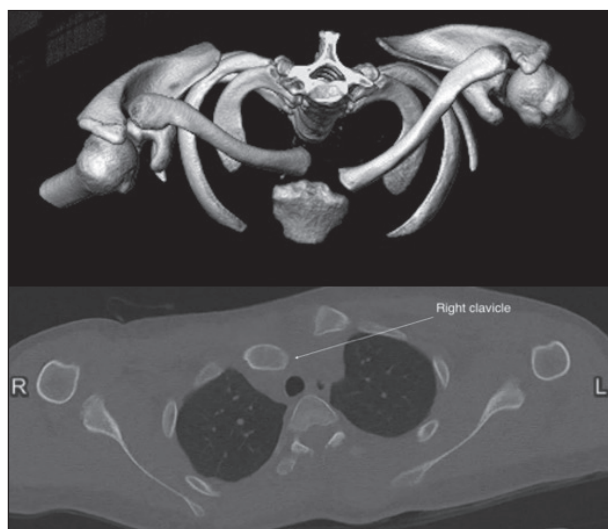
Pre-operative CT scan: posterior dislocation of the right SCJ
